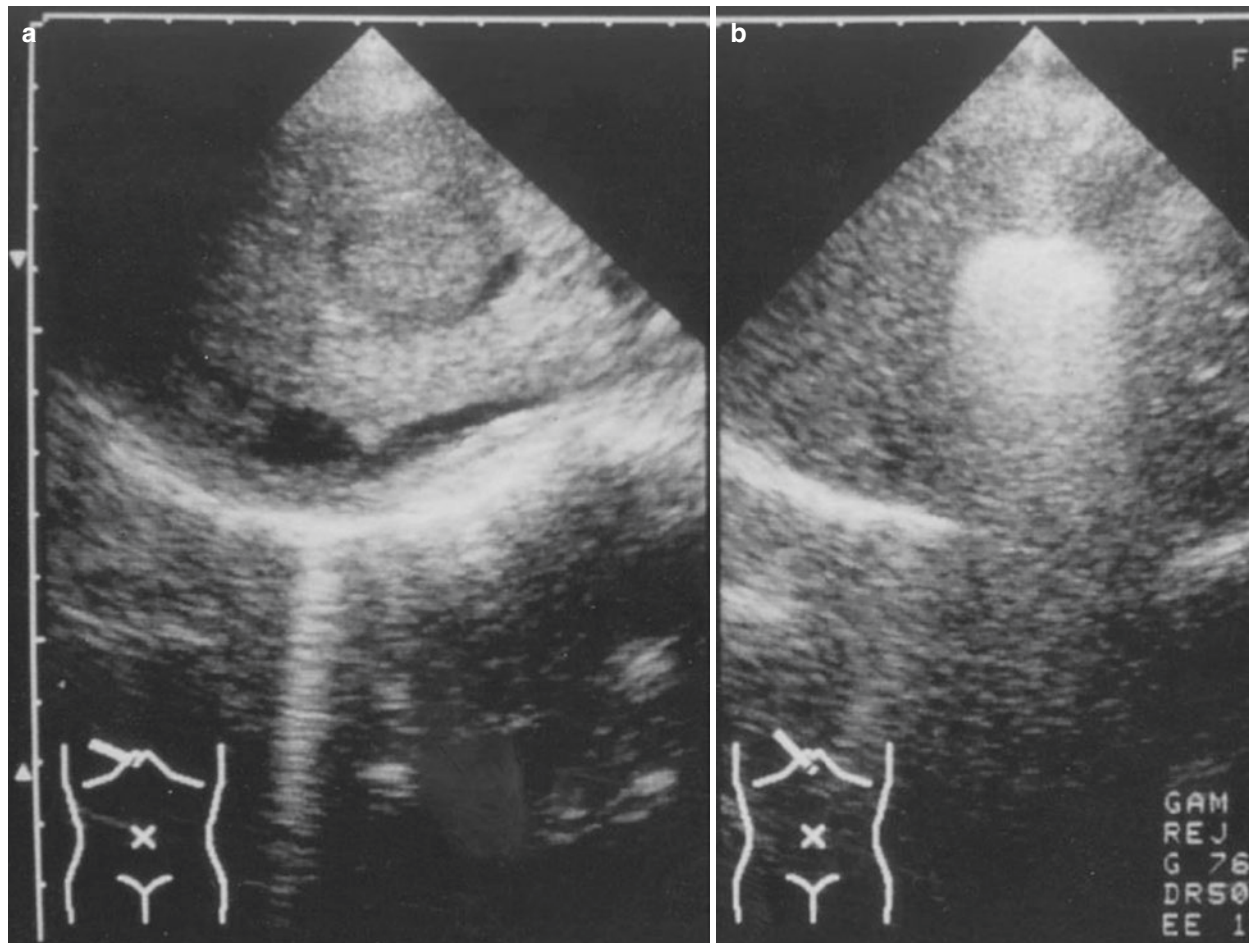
Percutaneous ethanol injection. Ultrasonography shows an isoechoic space-occupying lesion (SOL) with halo (a). Ultrasonography shows hyperechoic SOL after PEI (b). The tumor (upper right) is totally
